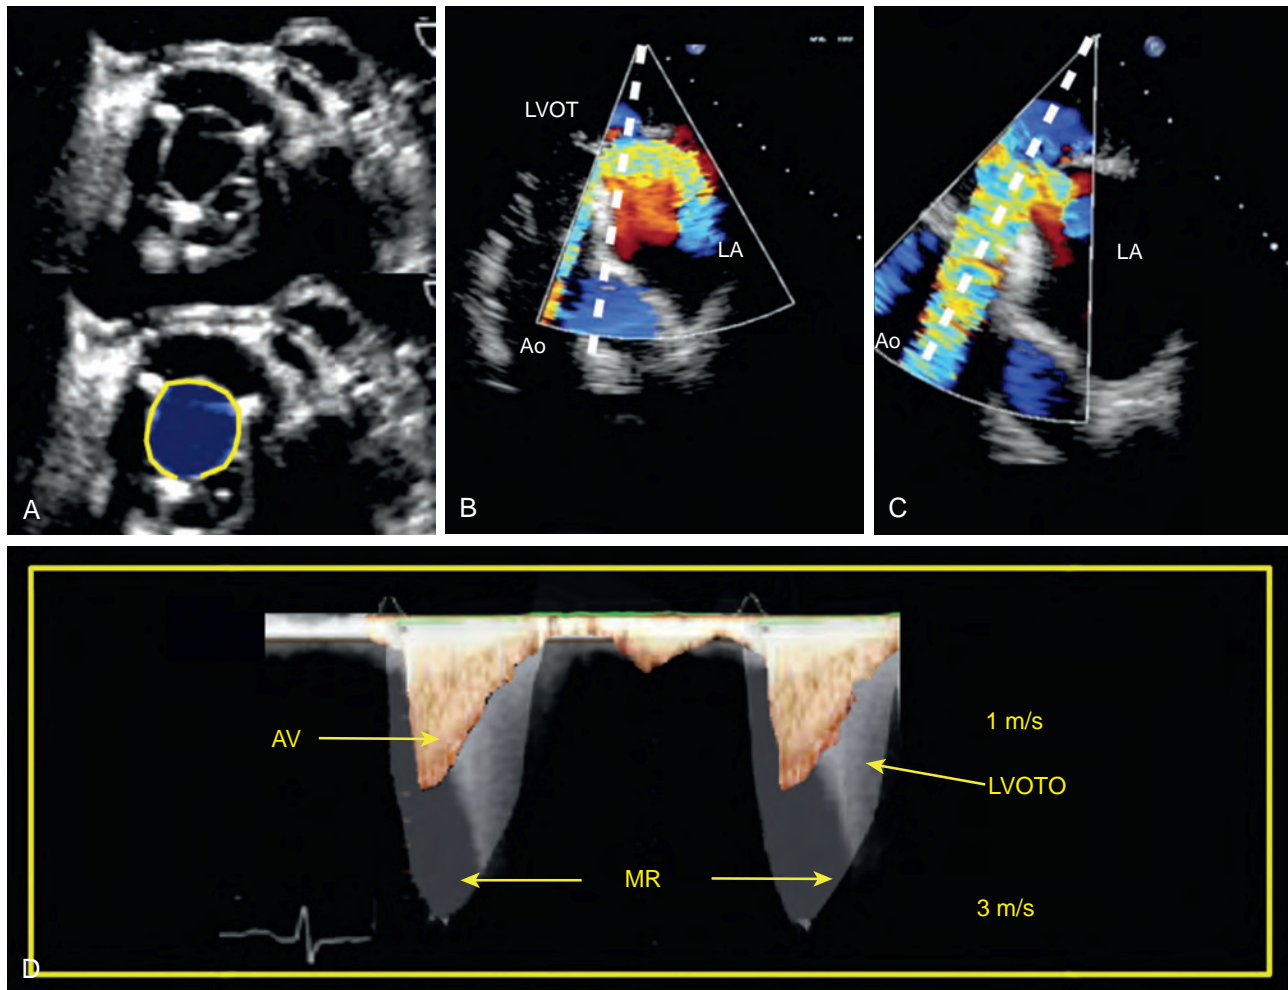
Flow profiles. (A) Short-axis view of a normally functioning bioprosthetic valve immediately after aortic valve replacement. (B) and (C) The period after bypass is complicated by dynamic outflow tract obstruction and mitral regurgitation (MR). (D) Three different Doppler flow profiles recorded during Doppler interrogation from transgastric windows. The valvular profile (AV) is lower velocity (approximately 1.5 m/s), early peaking (acceleration time < 80 ms). Left ventricular outflow tract obstruction (LVOTO) is a higher velocity late peaking profile. These are distinct from the holosystolic MR profile. Ao, Aorta; LA, left atrium.
